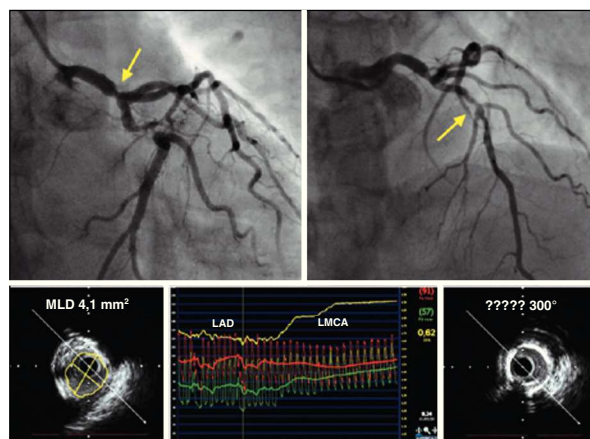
Lesion in the left main coronary artery (LMCA) + three vessels, Syntax 28. The right coronary artery was previously treated during an acute coronary syndrome. Lesions of LMCA and left anterior descending artery (LAD) were assessed by intravascular ultrasound and fractional flow reserve, demonstrating a need for revascularization. Sub-occlusive lesion in the proximal third of the left circumflex artery. MLD = minimum lumen diameter.
